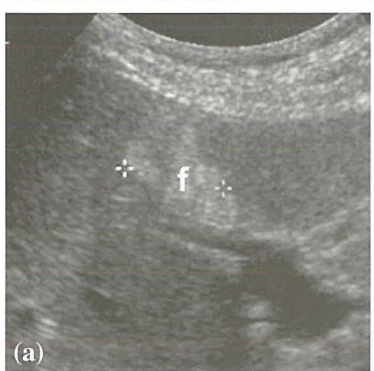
(a) Transverse US image shows a geographically shaped hyperechoic area (asterisks) anterior to the left portal vein and around the falciform ligament (f). (b) CT scan showing foci of fatty infiltration (darker areas) next to the falciform ligament (f) and anterior to the porta hepatis (p).
